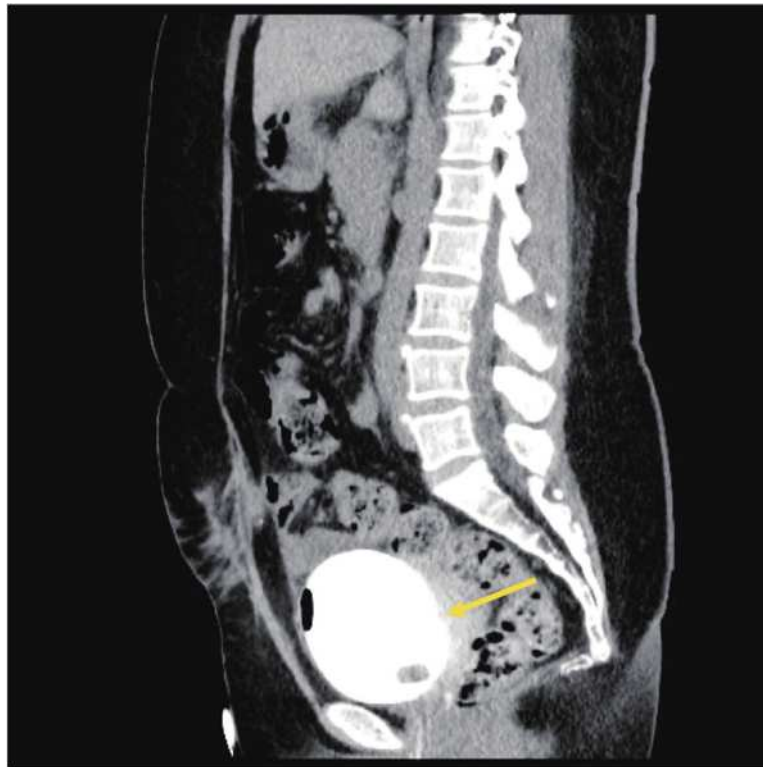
Contrast-enhanced CT of the abdomen and pelvis after treatment shows no extravasation to the pelvic cavity, while displaying irregular thickening on the posterior wall (arrow), suggesting probable bladder healing after the rupture. (Abbreviation:CT: computed tomography)
